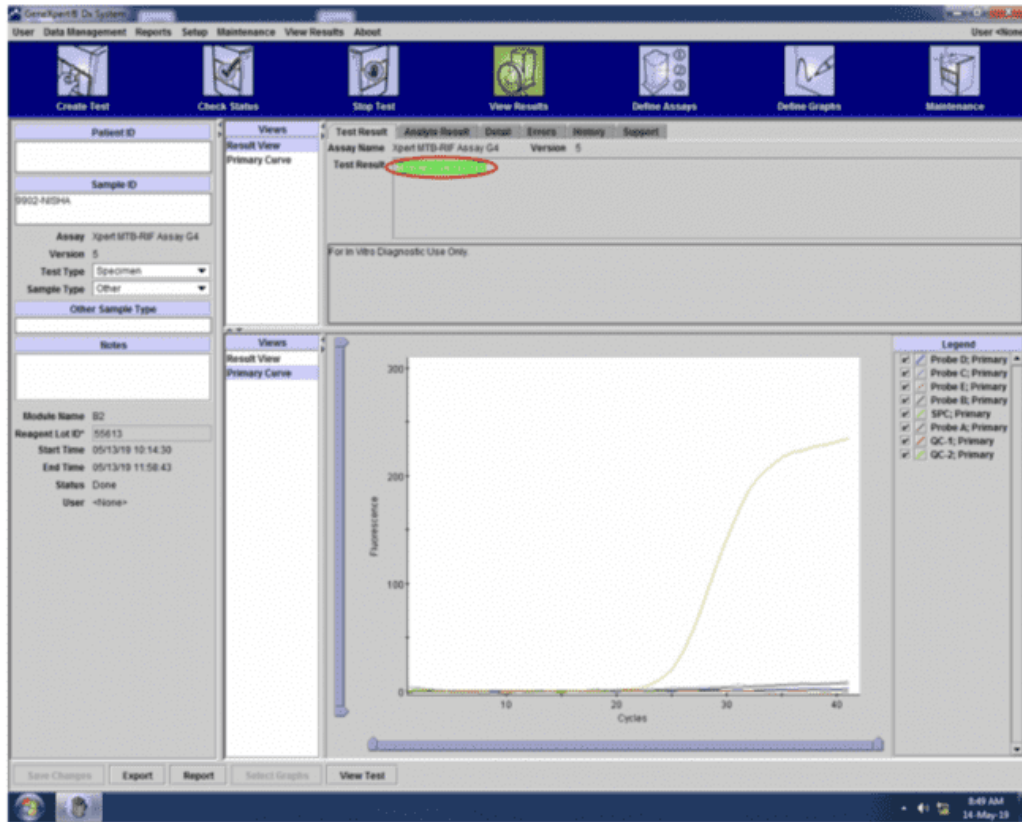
Result shown as MTB not detected since CT values for all the probe values are zero
